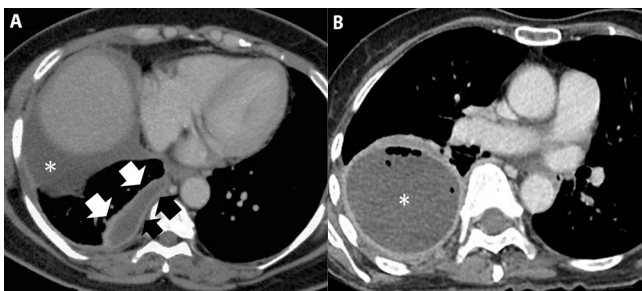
A: CT thorax study, with fluid interspaced between the visceral and parietal pleurae (white and black arrowheads respectively), giving signs of "split pleura". Both pleurae are smoothly thickened and mildly enhancing, due to the inflammatory/infective change. In contrast, note the more bland pleural effusion anteriorly (indicated by *) which lacks the associated finding of a thickened enhancing pleura. B: In this study, this fluid collection (indicated by *) is more rounded in configuration, with thick enhancing walls and a concavity of the visceral pleura. Small gas locules within this loculated empyema are secondary to recent aspiration, which yielded frank pus. Apparent midline shift is due to the underlying spinal scoliosis.
